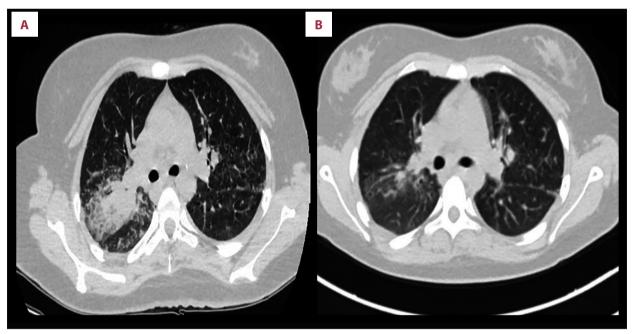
Contrast computed tomography (CT) comparison images of the pulmonary right upper-lobe consolidation with air bronchogram upper-lung infiltrates at the time of hospital admission (A) and after 6 months of treatment (B).
